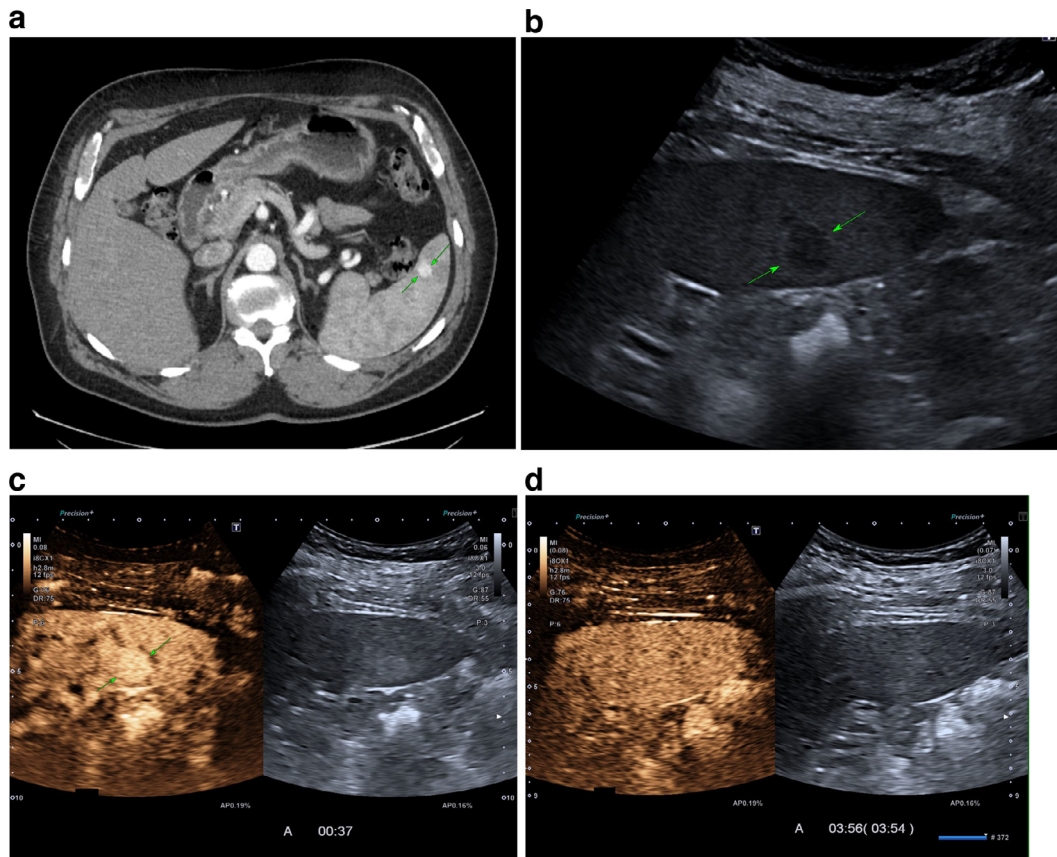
Presumed atypical benign vascular tumor of the spleen. Image from a renal mass characterisation protocol CT in a 61 year old man being investigated for a mildly complex renal cyst (not shown). The CT shows a small incidentally discovered hypervascular splenic lesion (a, arrows). On ultrasound the mass is echo-poor and cannot be characterised (b, arrows). Following injection of ultrasound contrast microbubbles the mass is hypervascular in the arterial phase (c, arrows), in the late phase the mass is iso-enhancing with adjacent spleen and difficult to identify (d). Although the grey scale morphology is unable to differentiate between a benign and malignant lesion, the ultrasound contrast appearances are characteristic of a benign lesion (likely benign vascular tumour). This case is suitable for ultrasound surveillance.
